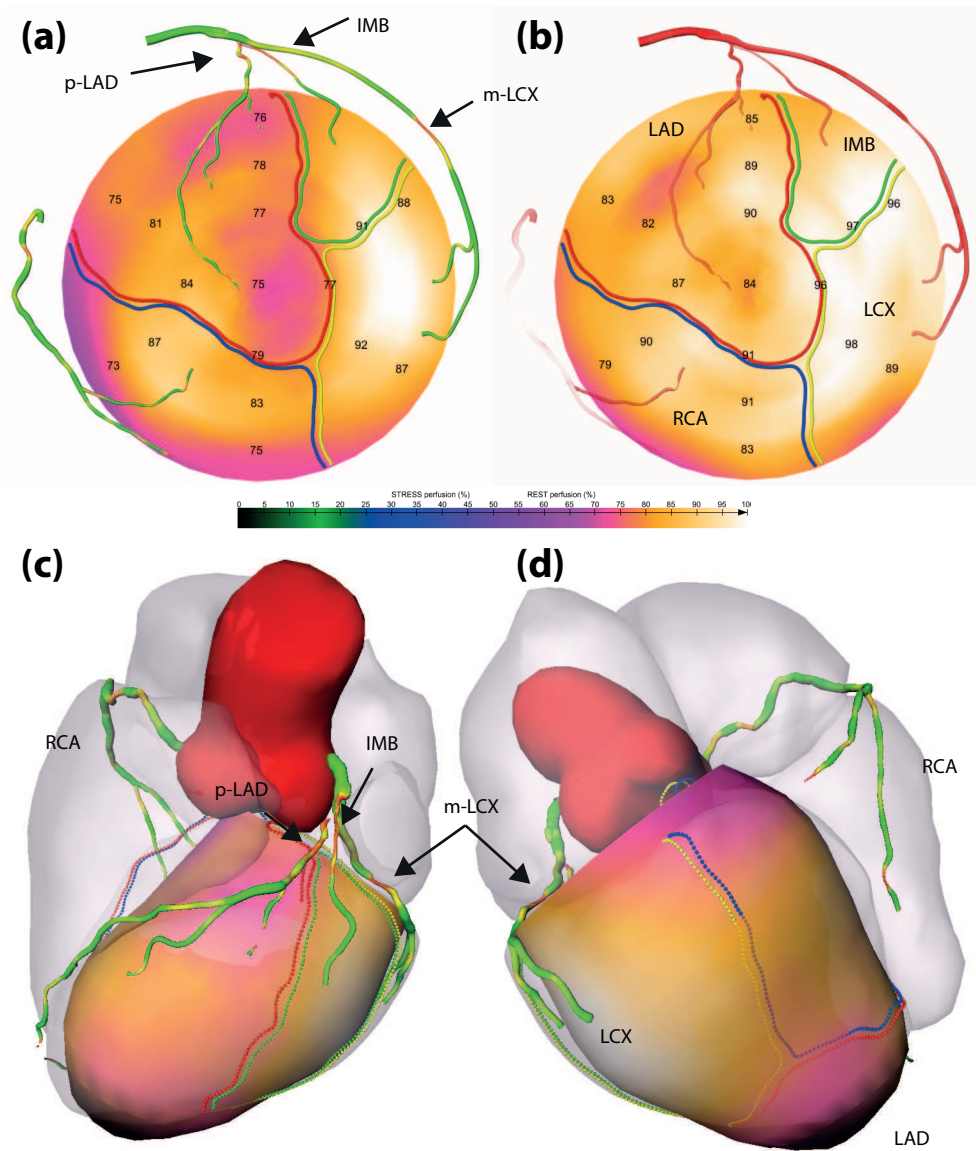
Example of patient 05 (65 y.o. male). (a) Stress polar map: the coronary vessel tree is color-coded with the automatically estimated degree of stenosis. (b) Rest polar map: the coronary arteries are coded with the distance to the epicardium: the more transparent the artery, the further it is from the epicardium. Patient-specific perfusion territories are also projected: LAD in red, LCX in yellow, MO in green and RCA in blue. (c)(d) 3D model of the heart and coronary artery tree extracted from CTA fused with 3D stress polar map.
